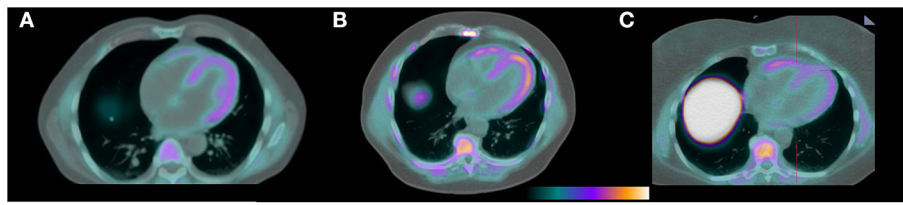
F18-florbetapir PET/CT images demonstrating identifiable myocardial uptake of radiotracer in the patient with confirmed cardiac amyloidosis by technetium PYP (A, mean myocardial SUV 3.3), a patient with light chain MGUS and a potential for having cardiac AL amyloidosis (B, mean myocardial SUV 2.7), and a control patient with a negative tenosynovial biopsy for amyloidosis at the time of carpal tunnel release surgery (C, mean myocardial SUV 2.0).
